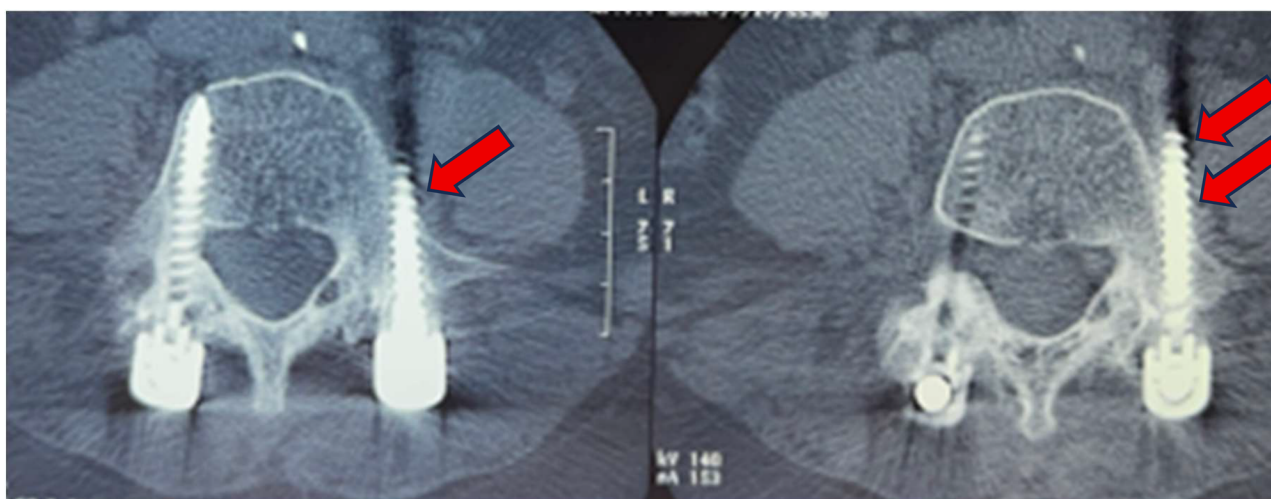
Computed tomography imaging demonstrates lateral misplacement of the left pedicle screw (arrows), leading to the exclusion of the patient from the study and prompting referral for further specialist evaluation
